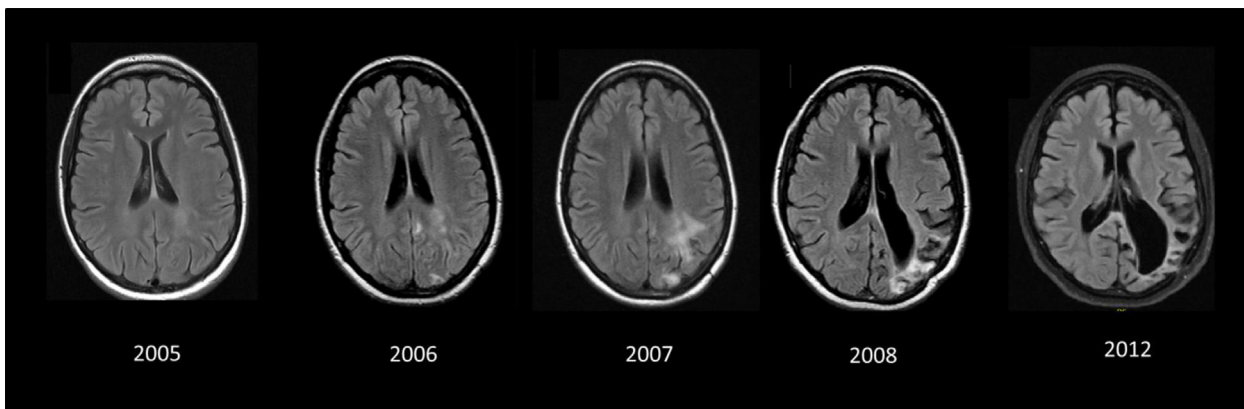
Serial axial T2/FLAIR weighted MRI brain in adult onset Rasmussen showing the progression of the condition in: 3 months, 17 months, 24 months, 32 months and 7 years after the disease onset. MRIs show multiple enhancing left hemispheric lesions involving primarily the temporal, parietal, and occipital lobes. Progressive left parietal and occipital cystic encephalomalacia and volume loss are very prominent between 2007 and 2008.
